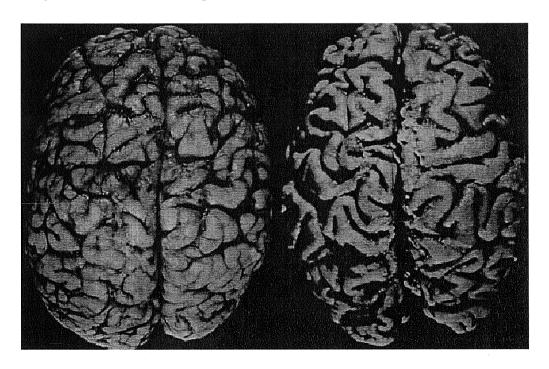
Brains from AD patients (right in both figures) show reduced metabolic activity (left-shown using MRI) and macroscopic (below - post mortem) differences including brain atrophy and loss of brain substance when compared to a healthy age matched control.
